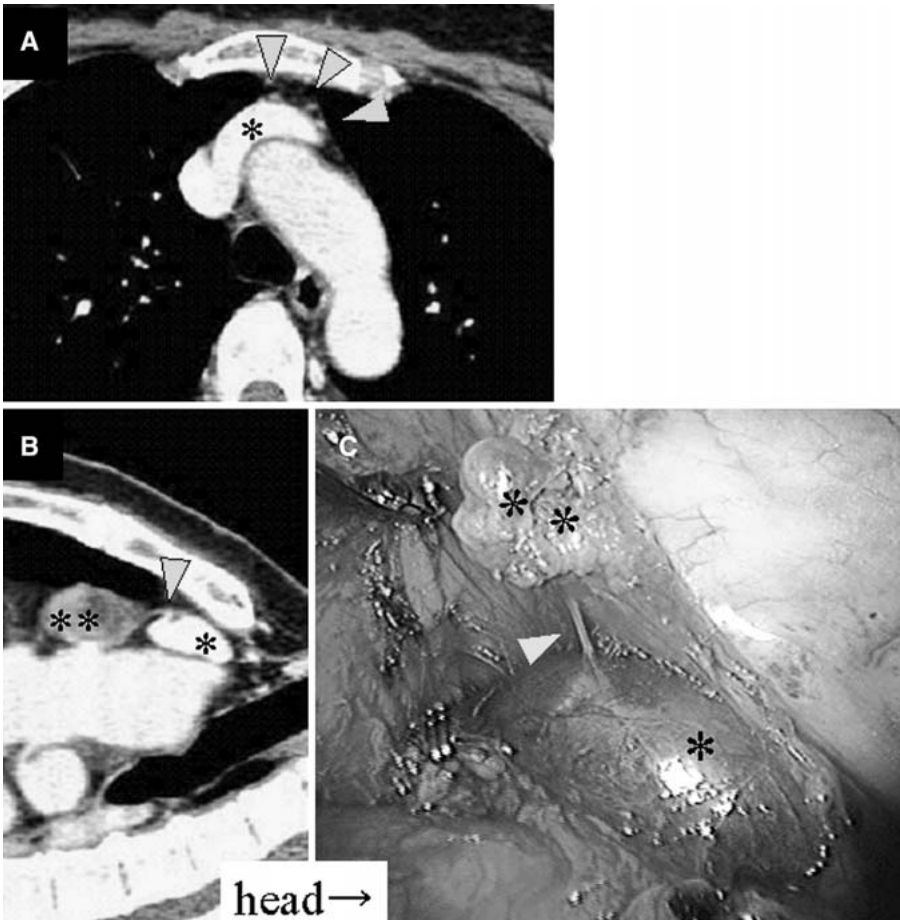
Multidetector-row computed tomography (MDCT) images and the intraoperative view obtained from patient 4 (Table). A Horizontal image showing three thymic veins. B One of the tributaries unusually runs upward into the superior side of the brachiocephalic vein (*yellow arrowhead*). C The corresponding thymic vein was safely divided by left-sided video-assisted thoracoscopic surgery. *The left brachiocephalic vein. The thymus.
